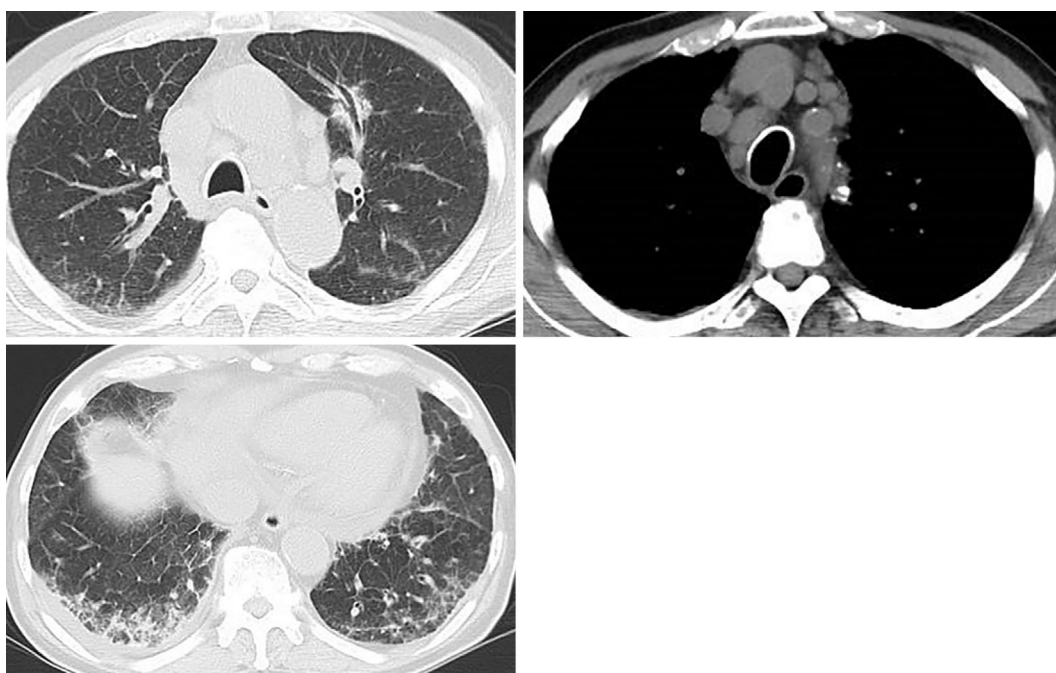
Chest computed tomography shows a nodule in the left lung, mediastinal lymphadenopathy, right pleural effusion, and bilateral lower lung infiltrates.
